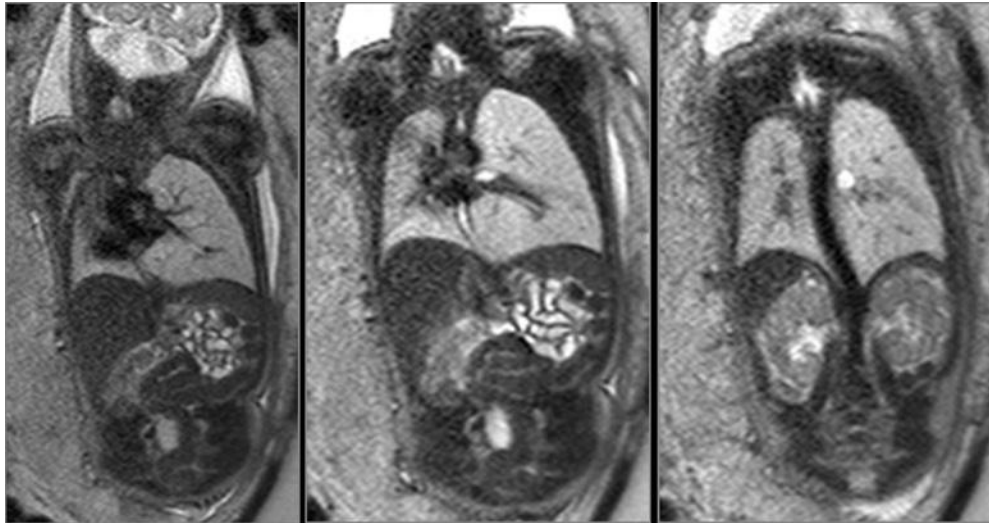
Coronal fetal magnetic resonance images showing unilateral hyperexpanded left lung. Note the left perihilar T2-weighted hyperintense structure consistent with a dilated, fluid-filled airway.
